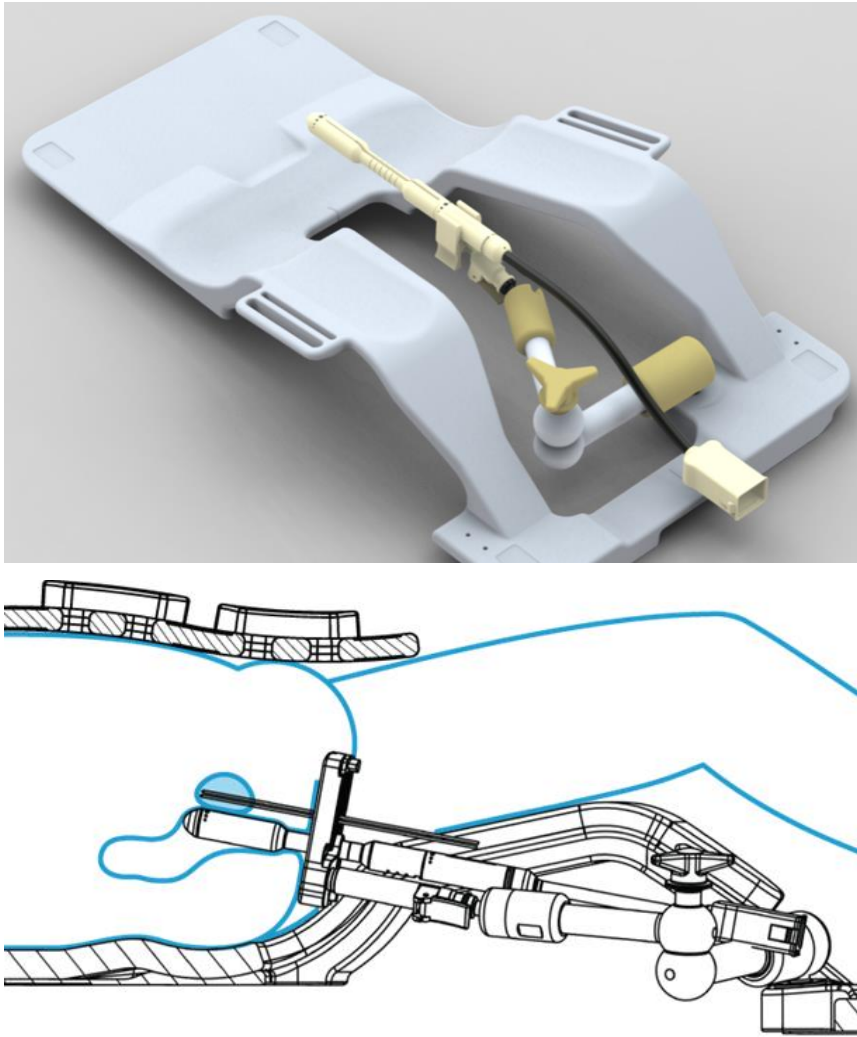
MRI setup system consisting of body coil, four-channel phased-array pelvic surface coil, and endorectal coil which is affixed with the perineal template.
